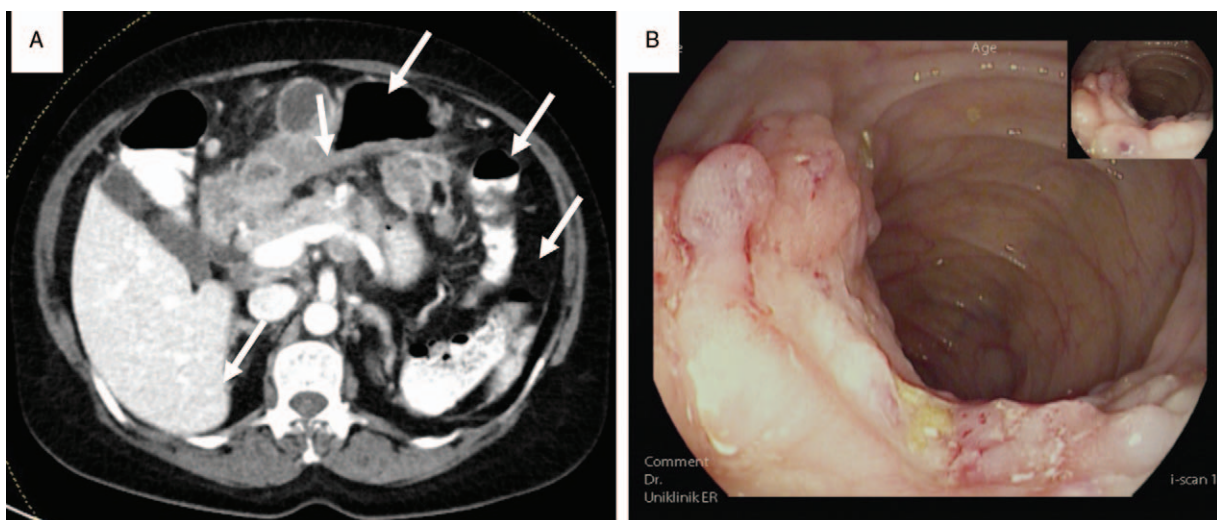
(A) Abdominal computed tomography scan showing multiple peritoneal lesions (white arrows) highly suspicious for a malignant process of unknown origin. (B) Colonoscopy showing an exophytic and ulcerating tumor in the right transverse colon.
